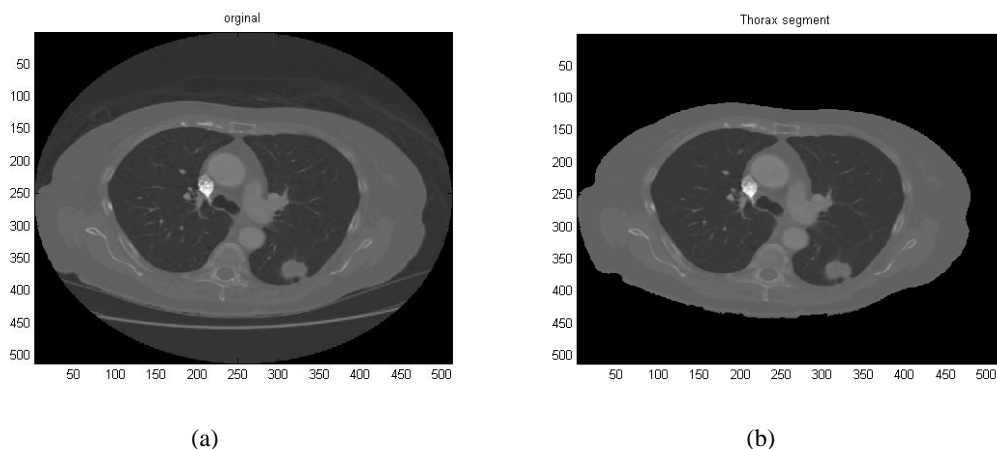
(a) Computed Tomography image; (b) Thorax region extracted.
